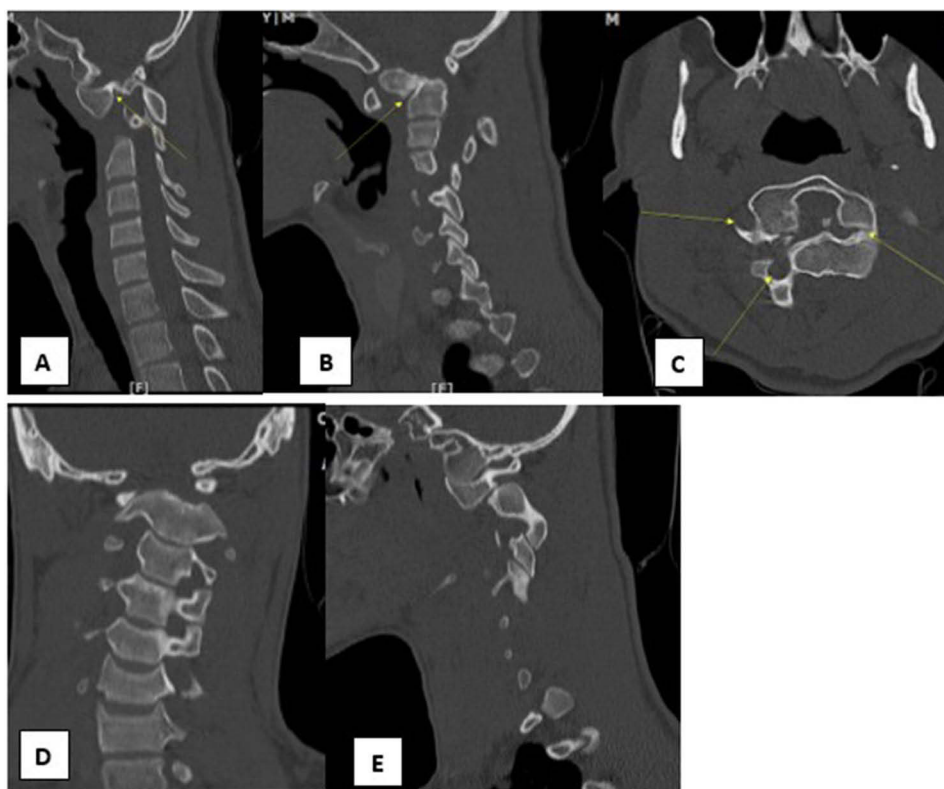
Preoperative CT scan of cervical spine sagittal, coronal, and axial view; malunited complete anteriorly slipped right atlantoaxial facet (A), malunited complete anteriorly slipped of (B), departed foramen transversarium of C1 and C2 on the right side, indicating unilateral AAS (C), right torticollis as a result of right AAS (white arrows) (D) and near complete atlantoaxial subluxation on the left side (E).
